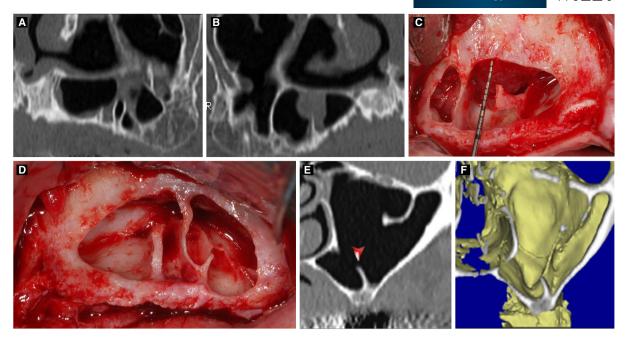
A, B, Cone beam computed tomography depicts multiple septa aligned with a buccal/palatal orientation. C, D, Clinical photographs show septal preservation following sinus membrane elevation. E, F Cone beam computed tomography depicts a mesiodistal-oriented septum; three-dimensional rendering of the sinus more clearly denotes septum direction and morphology. A buccal-palatal septum is visible in the posterior recess
